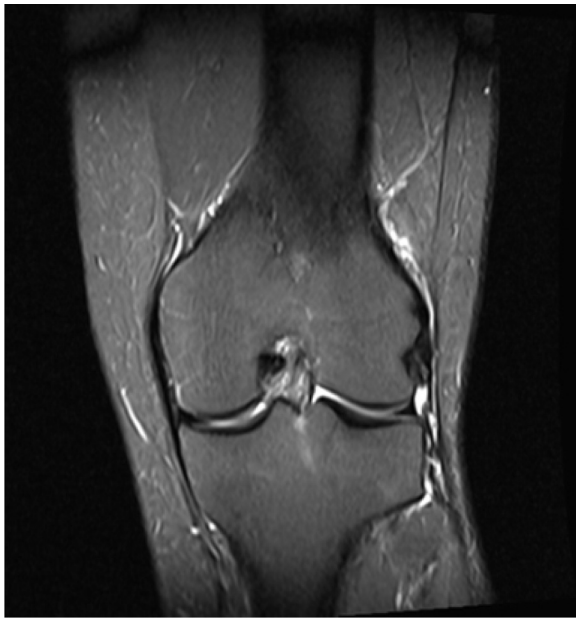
A follow-up MRI of the left knee showing resolution of the osteomyelitis in the left femur after 18 months of therapy.
